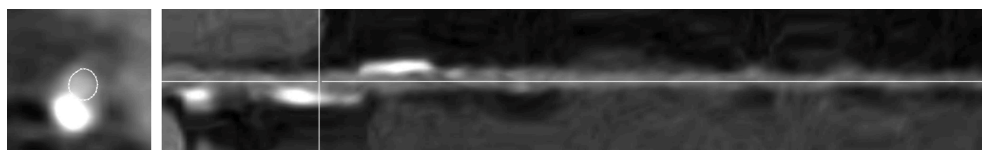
Multiplanar reformatted view of a vessel in a computed tomography coronary angiography image. The white cross on the long-axis view (right) shows the position of a calcified plaque. It is synchronized with the short-axis view (left), on which the vessel segmentation (white contour) is overlaid.
